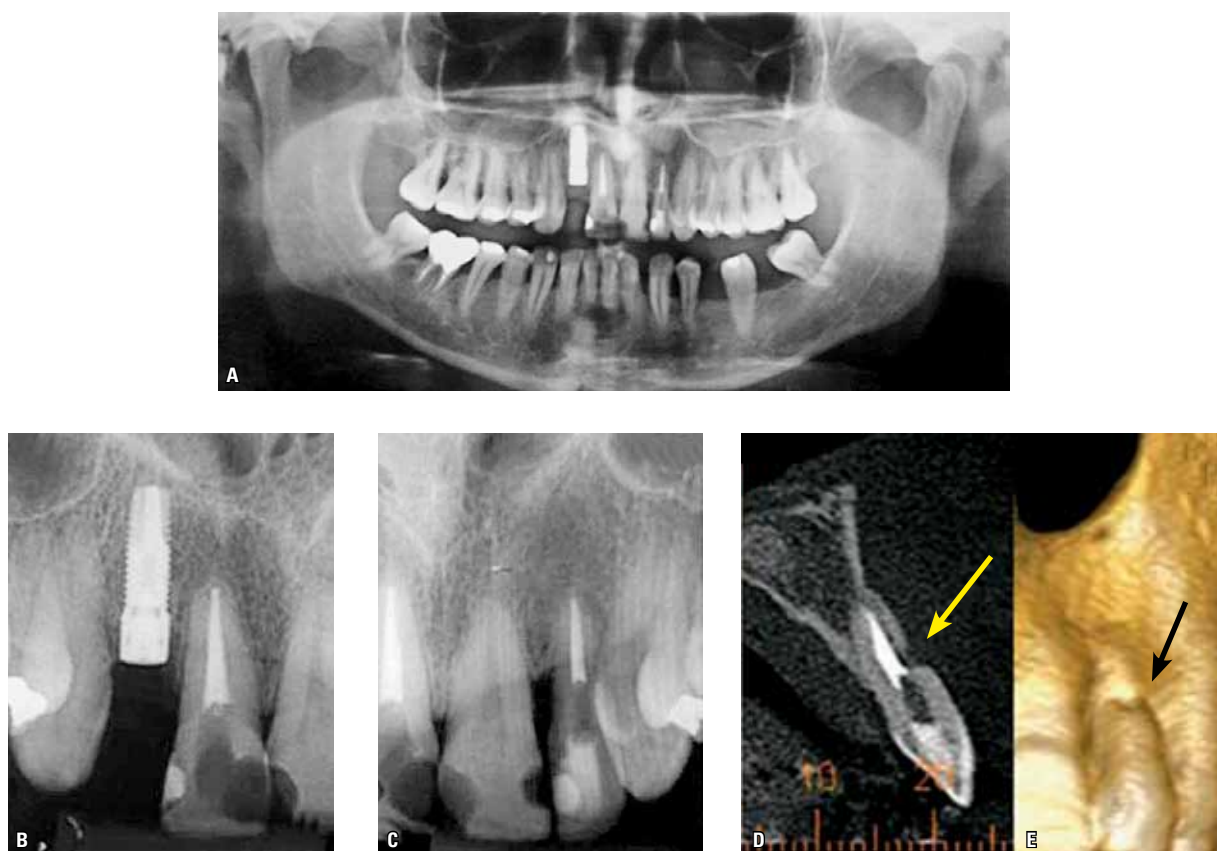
A) Endodontic treatment of teeth 11, 22 and 46. Increased periodontal space on tooth 46 and B) presence of implant in the region of tooth 12. C) Detail of the region of upper anterior teeth. D) CBCT of tooth 22. Absence of vestibular cortical bone and root resorption in the middle third of the buccal root of tooth 22 and E) 3D reconstruction. Note the bone loss and root resorption in tooth 22.
